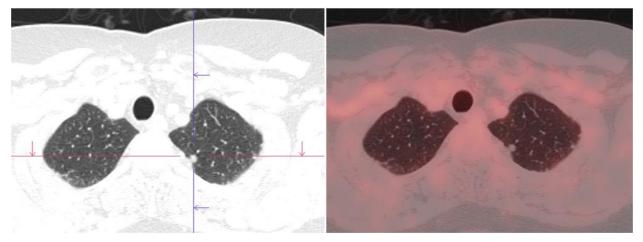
A 67 year-old woman with a history of bilateral ductal carcinoma, who was referred for PET/CT because of suspected recurrence of the disease based on the detection of litigious lung nodules on CT. TMs were slightly elevated. PET/CT showed no FDG uptake in these lesions, because of their small size.
